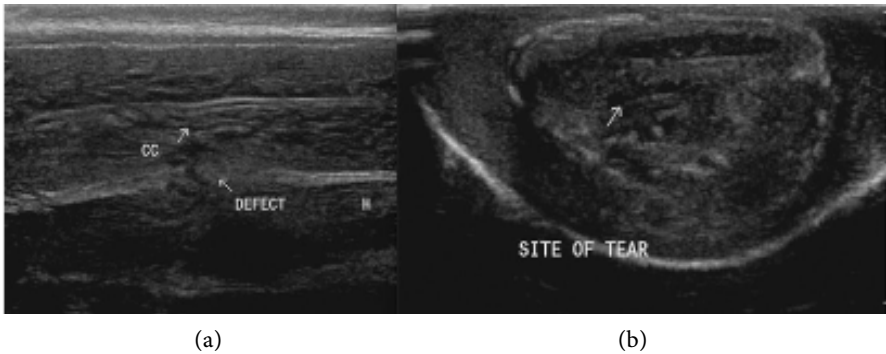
Ultrasound image showing a rupture of the tunica albuginea of the corpora cavernosa, confirming a penile fracture.
